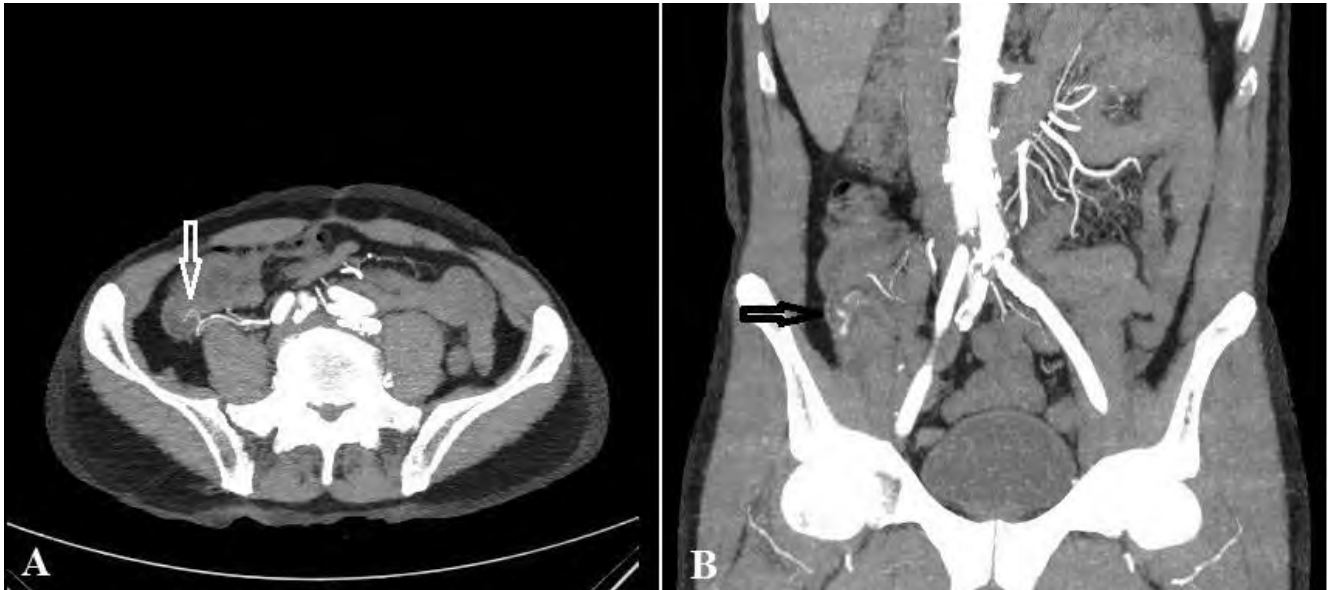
The bleeding caecal angiodysplasia on two images (A, B) of CT-angiography (arrows show the lesion located at the medial wall of the caecum)
